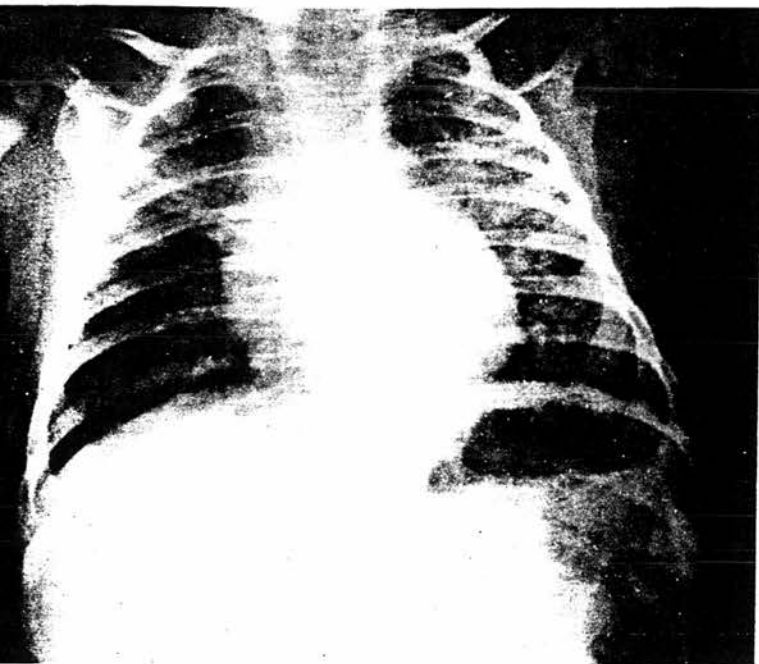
Chest radiograph showing bilateral interstitial pneumonitis.
